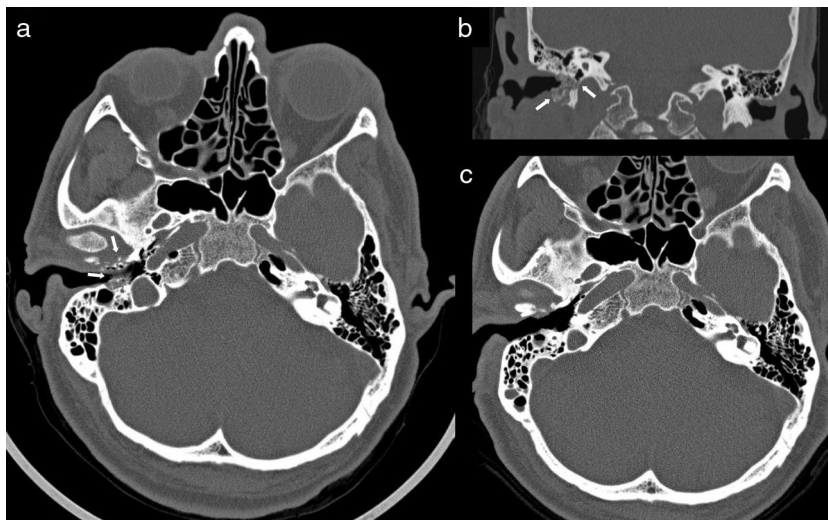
Computed tomography (CT) of ears and mastoids with axial (a) and coronal images (b) performed at the time of diagnosis of skull base osteomyelitis associated with right malignant otitis externa (MOE), which shows areas of osteolysis affecting the anterior and posterior walls and the floor of the external auditory canal, with sequestrations and small gas bubbles inside the compact bone and increased soft tissue inflammation (white arrows); (c) follow-up CT performed five months after surgical debridement and after a 3-month cycle of antifungal treatment confirming the resolution of MOE and of the osteomyelitis component.
